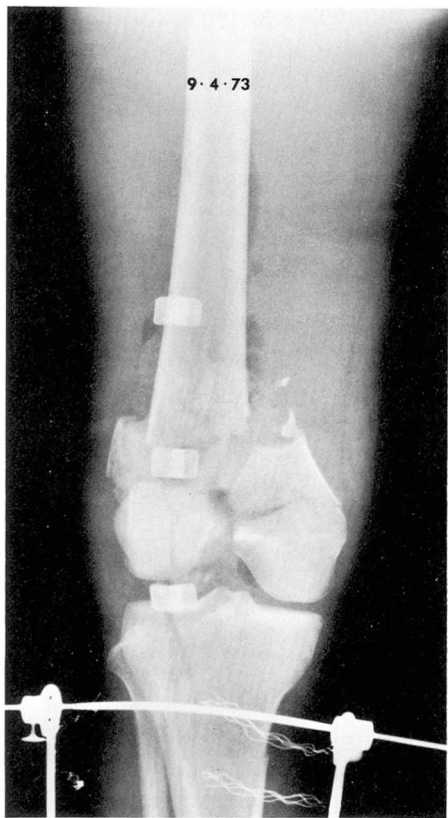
Roentgenogram of right femur and upper tibia-fibula, showing compound fracture of distal femur and gas in soft tissues. The roentgenogram was taken before the onset of *Bacteroides fragilis* bacteremia which lasted 24 days.
